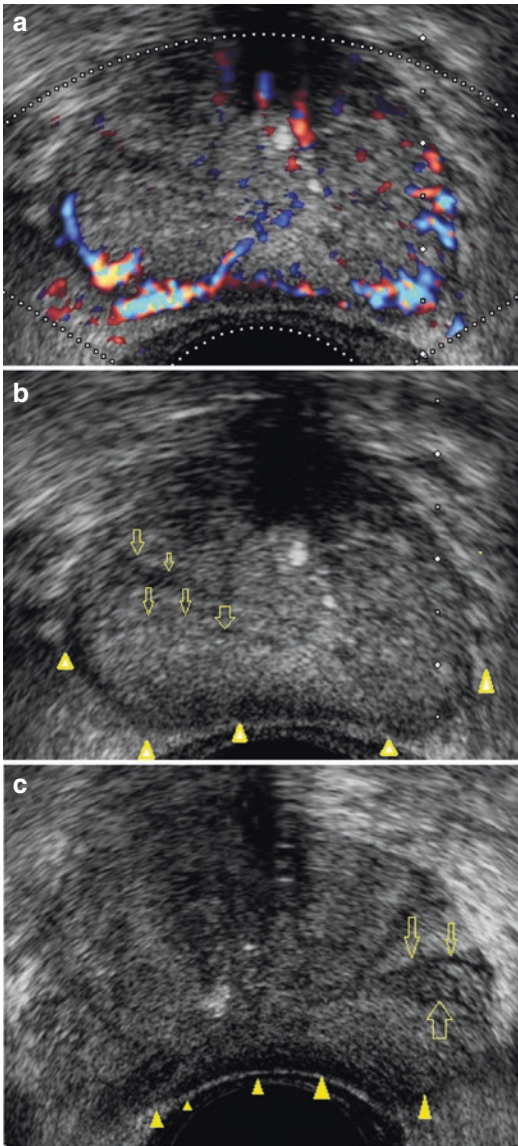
(b, c) Acute prostatitis: subcapsular hypoechoic rim (*arrowheads*) and fine hypoechoic linear septum (*arrows*) due to edema and ducts dilatation. (a) Color power Doppler shows an increased flow
